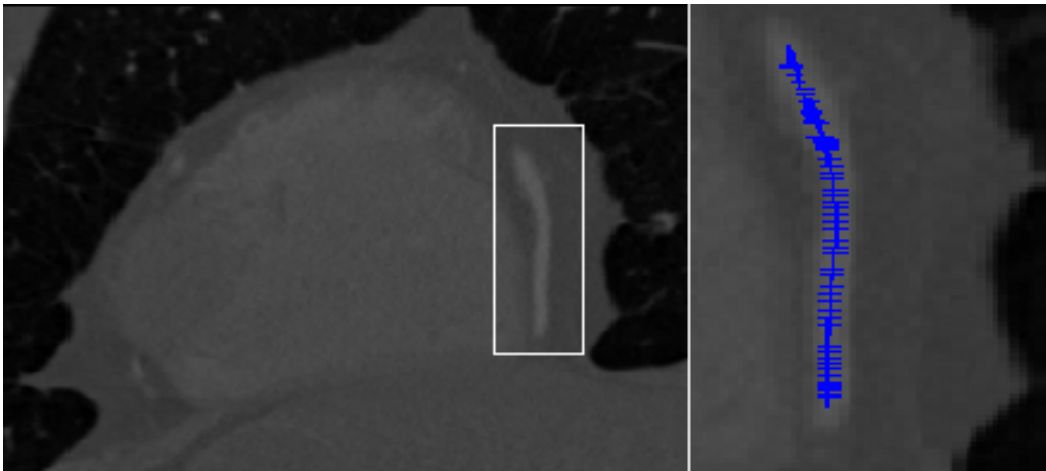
Good quality CTA image and extracted coronary artery centreline. Left: CTA slice with the rectangle marking the region of interest. Right: extracted coronary centreline marked with blue crosses from the CTA image on the left.
